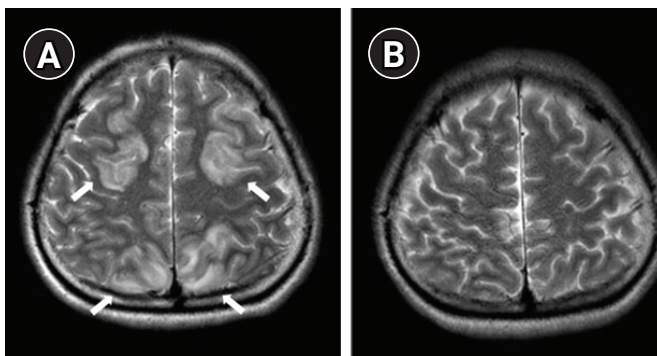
Brain magnetic resonance imaging performed on POD 10 (A) and POD 21 (B). Axial T2-weighted images (A) revealed signal intensity changes in both the frontal and parietal cortices and in the subcortical white matter (white arrows). POD 21 images (B) revealed complete remission. POD, postoperative day.
